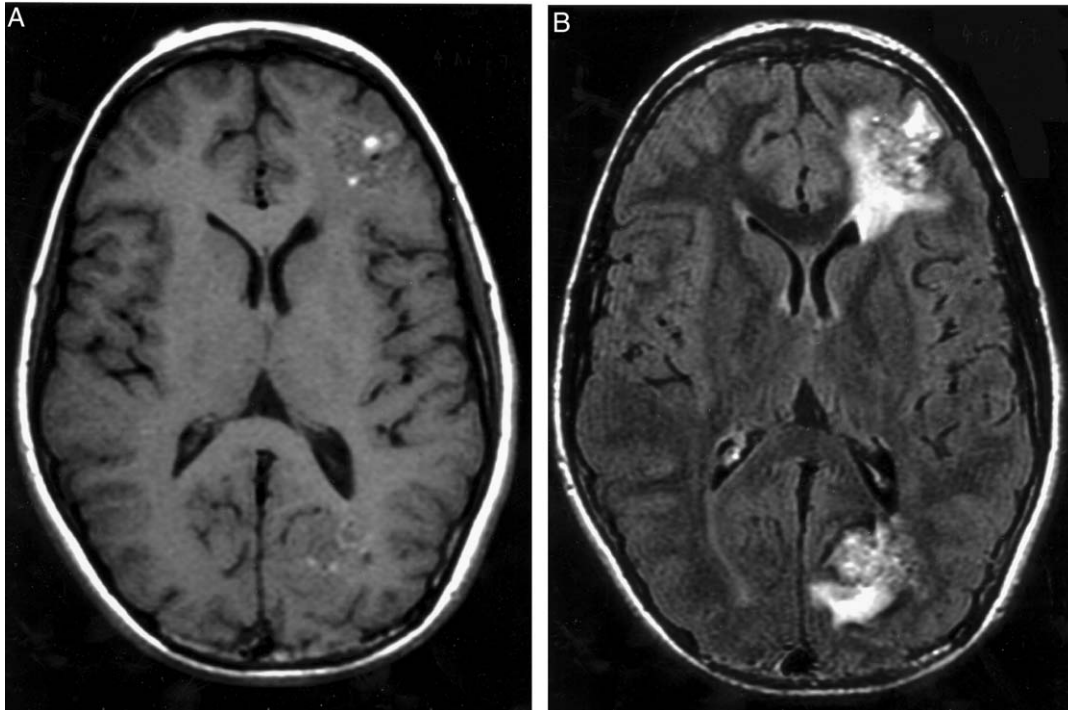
A, T1-weighted axial MRI. Complex isointense and hyperintense signal is observed in both a left frontal and left occipital lesion found in a 13-year-old male who presented with seizures. Investigation revealed 4 supratentorial lesions: 1 in the left frontal lobe (shown), 1 in the left occipital lobe (shown) and 2 lesions in deep white matter tracts (not shown). Because the patient's seizures were intractable to medical therapy the patient underwent successful surgical resection of the lesions. These hypointense and hyperintense lesions are most consistent with type 2 lesions. (Radiology section.) B, Flair image, axial MRI. Isointense to hyperintense signal is identified in the 2 supratentorial lesions. Associated edema is observed surrounding the left frontal lesion.
